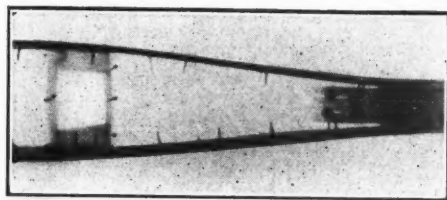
Radiograph of aero-plane hollow "box" strut, showing badly fitting internal end-block split by screws (Kaye & Knox).
